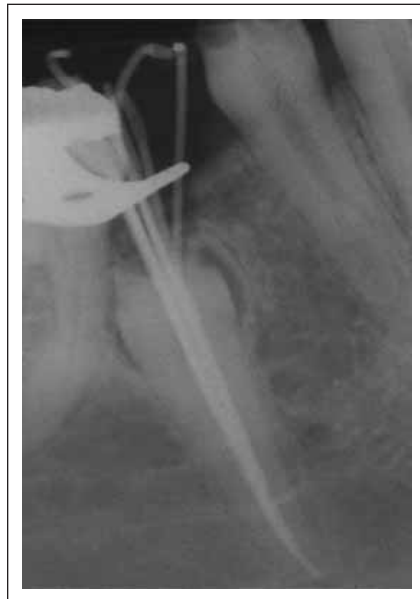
Partial fill radiograph.
